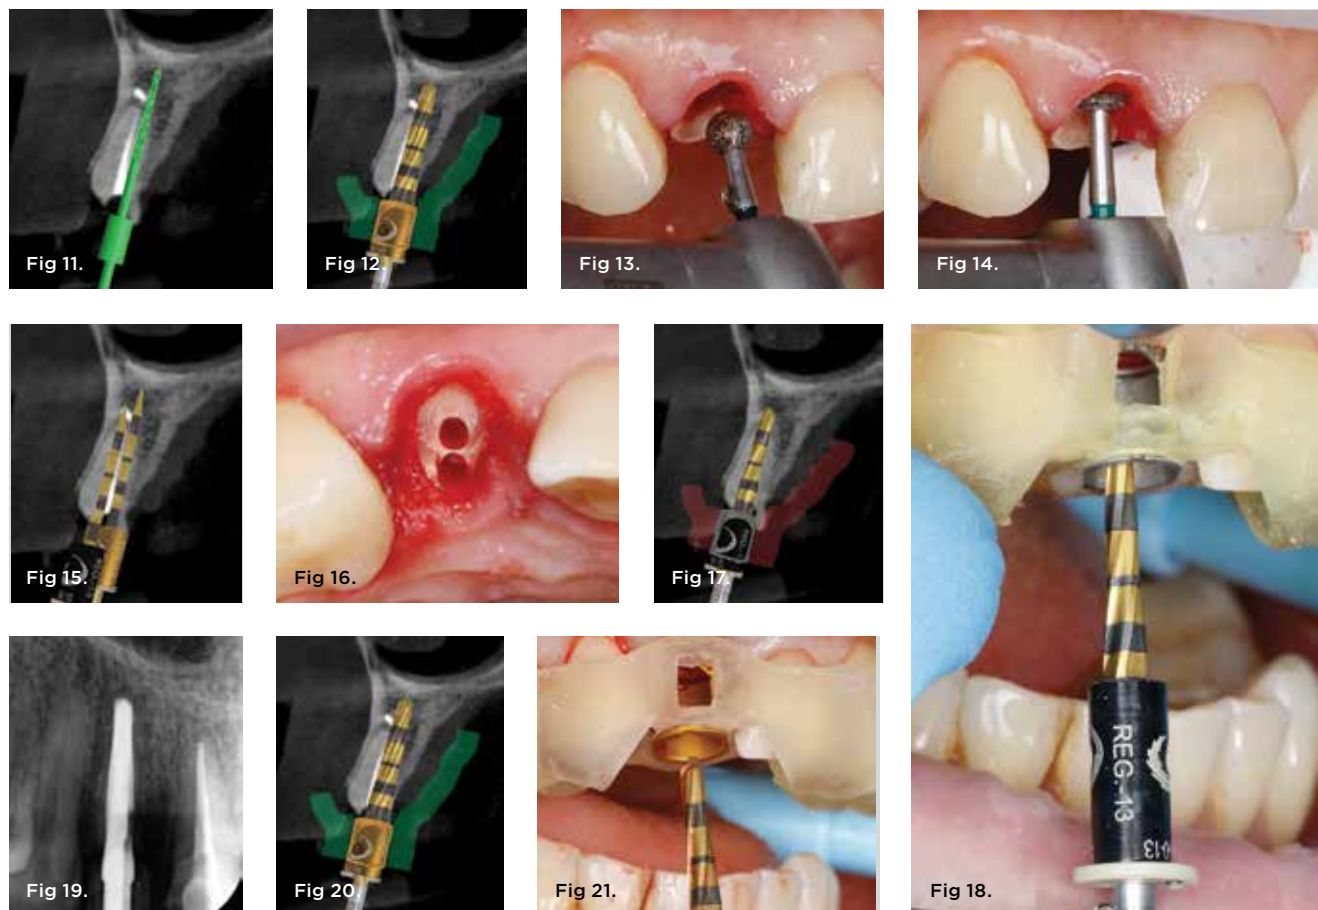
and Fig 12. Static Guide Two plan: produce implant site preparation guide using the medium C-guide with guided pilot (Fig 11) and Densah burs VT1525, VT1828, and VT2535 (Fig 12). Fig 13. Step 1: High-speed 3-mm diameter diamond bur (Meisinger 801H-029) is used to hollow out the middle of the tooth. Fig 14. Step 2: Diamond wheel bur (Meisinger 909G-031) is used to establish the restorative zone and flatten the root to bone level. Fig 15. Step 3: Two guided pilot hole trajectories are planned and executed using two separate static guides with guided Densah pilots. The root canal pilot trajectory is initiated with a high-speed bur (Meisinger HM162SX-014) to clear root canal contents and remove any filling material. Subsequently, the first static guide with a small C-guide (root canal/apex removal guide) is used with a guided Densah pilot equipped with a small gauge and G-stop operating in CW mode at 1,000 to 1,100 rpm with adequate irrigation to establish the first trajectory. The second static guide (implant guide) with a medium C-guide is used with a guided Densah pilot equipped with a medium gauge and G-stop operating in CW mode at 1,000 to 1,100 rpm with adequate irrigation to establish the implant site pilot trajectory. Fig 16. Clinical view of the two pilot trajectories achieved in Fig 15. Fig 17 and Fig 18. Step 4, apex removal trajectory: The first static surgical guide (apex removal and socket-shield preparation guide) using a small C-guide (Fig 17). Guided Densah burs VT1525 (2.0) and VT1828 (2.3) equipped with small gauge and G-stop are used with the first static surgical guide in CW mode at 1,000 to 1,100 rpm with adequate irrigation to further widen the root canal pilot hole and completely remove the apex (Fig 18). Fig 19. Apex removal is confirmed by radiograph. Fig 20 and Fig 21. Step 4, implant site preparation trajectory: The second static surgical guide (implant site instrumentation guide) digital design using a medium C-guide (Fig 20). Guided Densah burs VT1525 (2.0) and VT1828 (2.3) equipped with medium gauge and G-stop are used with the second static surgical guide in CW mode at 1,000 to 1,100 rpm with adequate irrigation to further prepare the implant site osteotomy. Subsequently, guided Densah bur VT2535 (3.0) equipped with medium gauge and G-stop (Fig 21) is used in CCW mode at 1,000 to 1,100 rpm with adequate irrigation to allow for bone and dentin particles autografting into the alveolar trabecular space. A post-implant site preparation radiograph (not shown) is then taken.
